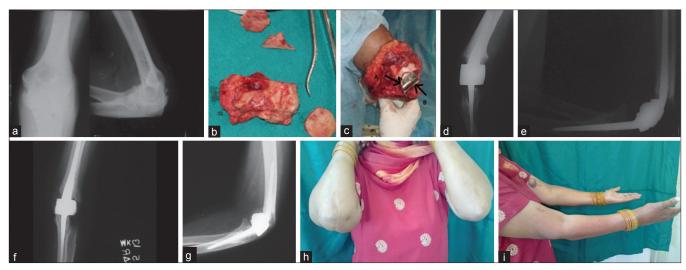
(a) Preoperative X-ray of right elbow joint (anteroposterior and lateral views) in a rheumatoid arthritis patient showing ankylosis of elbow in 90° flexion (b) photograph showing the excised part of fused elbow joint of the right side (c) photograph showing the humeral and ulnar hinged section of Baksi implant (black arrow) (d-e) Postoperative X-rays showing Baksi implant *in situ* (f-g) Final followup X-rays of right elbow (anteroposterior and lateral views) showing Baksi implant *in situ* without any signs of loosening (h-i) Clinical photographs showing flexion and extension of both elbow joints and surgical incision scar mark on posterior aspect of right elbow
